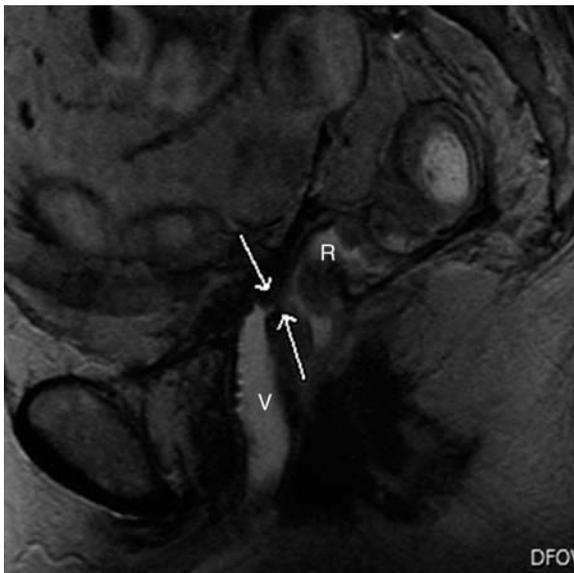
Rectovaginal fistula in a 67-year-old female. Sagittal T2-weighted image demonstrates high signal intensity gel in the rectum (R) and extending via a rectovaginal fistula (arrows) into the vaginal canal (V).
